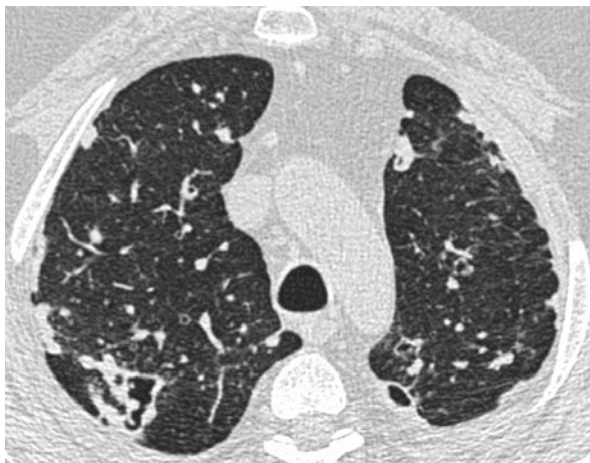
Axial HRCT image in a patient with rheumatoid arthritis and confirmed pulmonary artery hypertension on right heart catheterisation studies. There is gross enlargement of the main pulmonary artery
